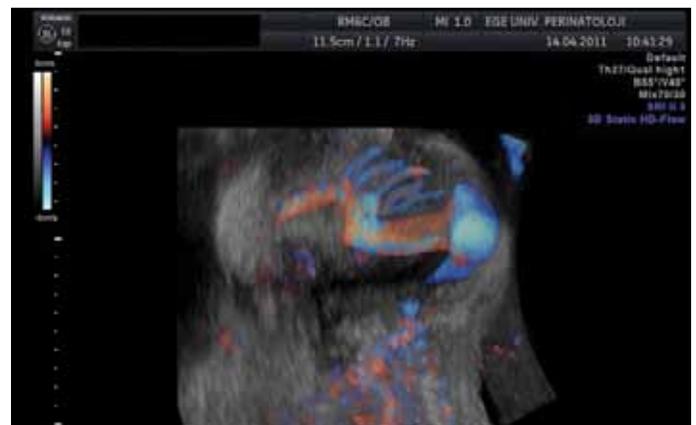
3D power Doppler investigation reveals more detailed anatomic plans without disadvantages of other sonographic modes
